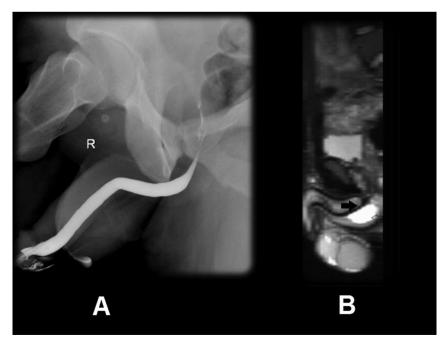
(A) Retrograde urethrogram was normal. (B) Reconstructive sagittal view of a T2-weighted MRI image revealed an oval-shaped, high-intensity cyst indicative of Cowper's syringocele (light arrow) at the posterior aspect of the bulbous urethra (dark arrow).
